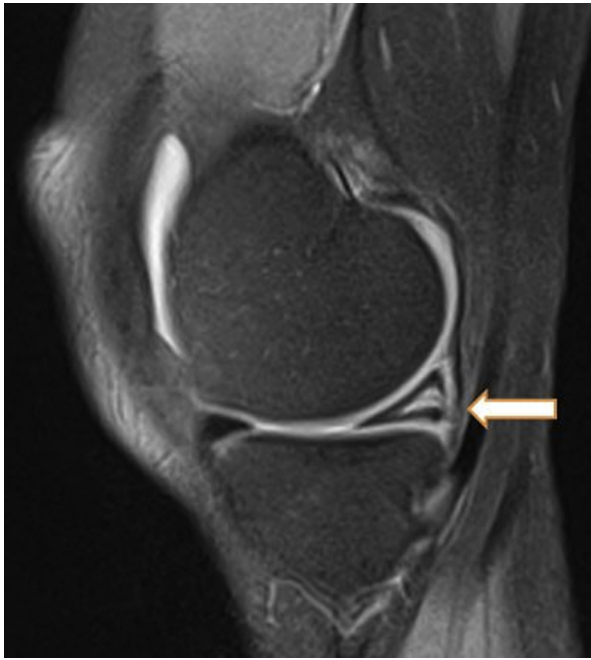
Sagittal magnetic resonance imaging scan of the right knee reveals excessive degenerative changes in the posterior part of the medial meniscus (so-called empty medial meniscus).
